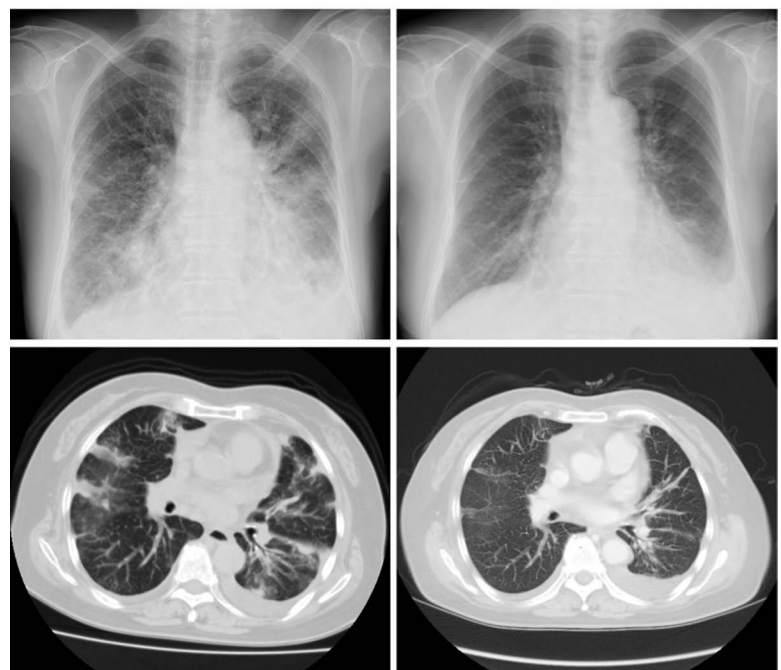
Chest radiography (upper panels) and CT (lower panels) before and after treatment with crizotinib. Chest radiography and chest CT examination after treatment were performed on the 28th day and on the 22nd day in the hospital, respectively. CT, computed tomography.
